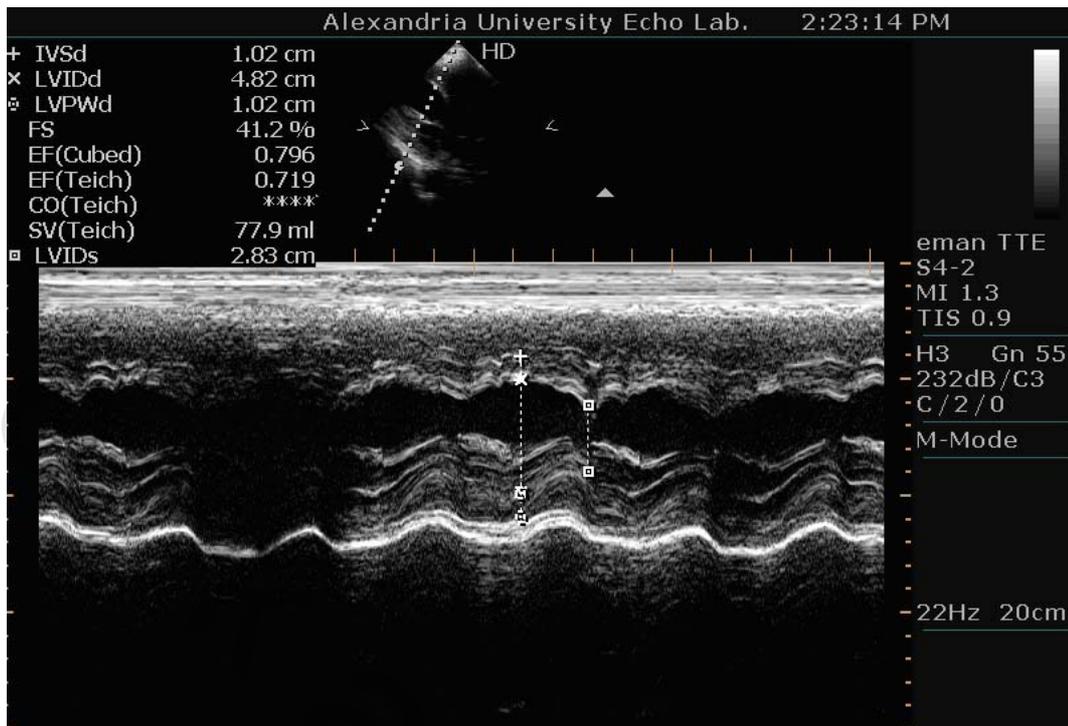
Conventional echocardiographic to assess EF before dialysis.
